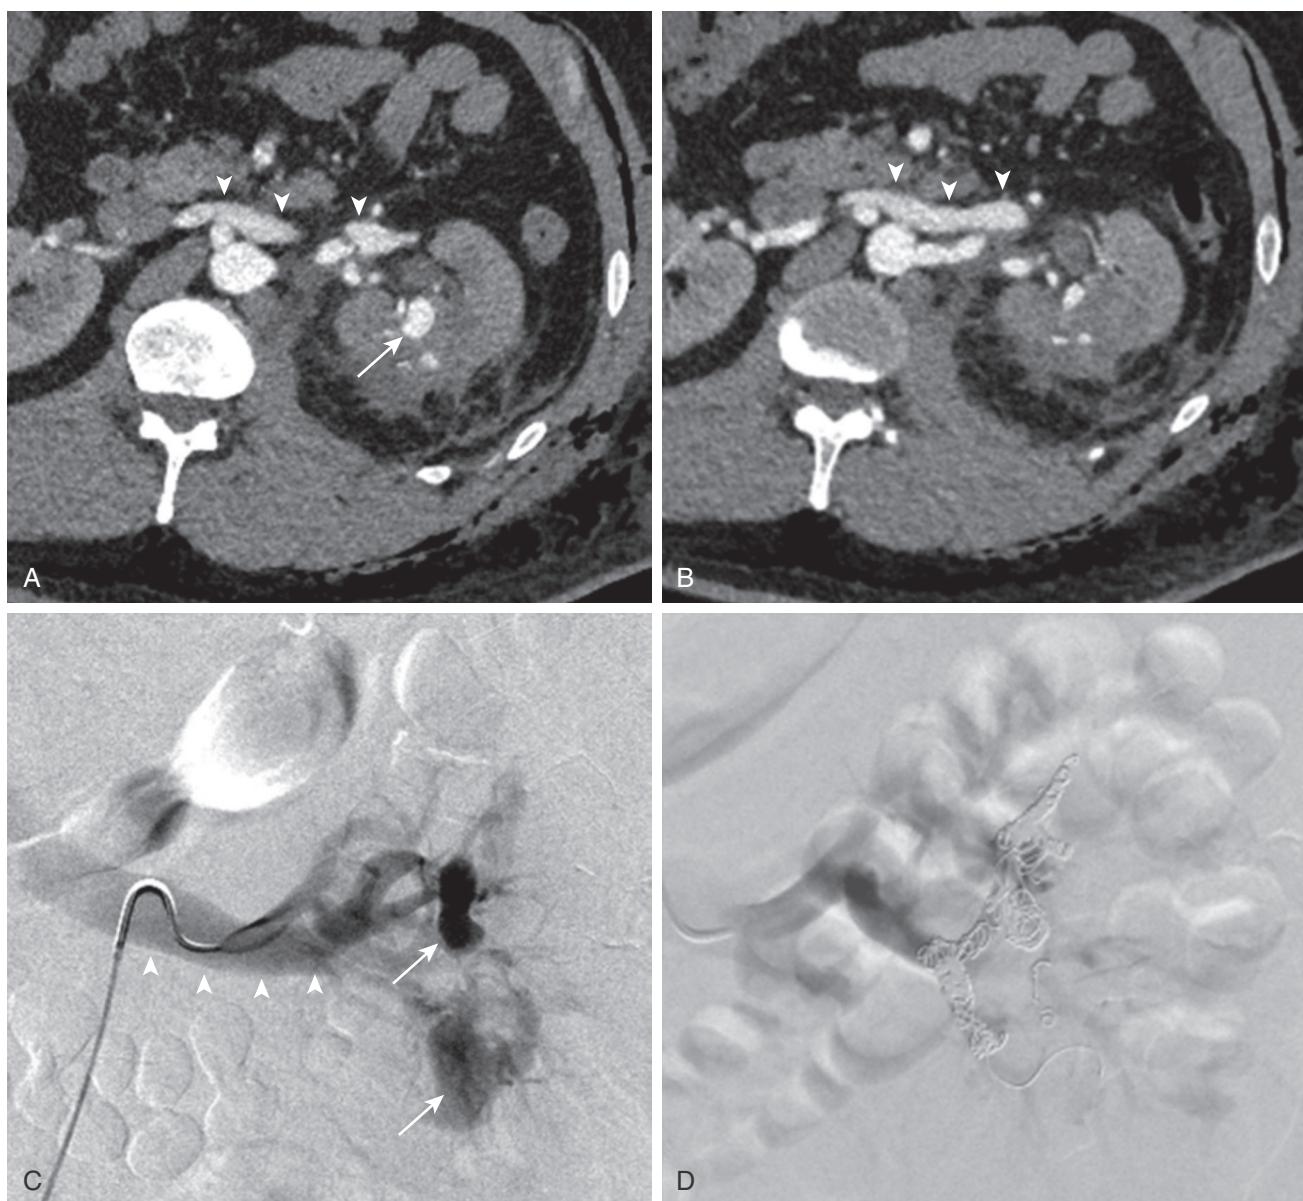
CT and angiogram of a patient with iatrogenic left renal pseudoaneurysms (PSAs) with an arteriovenous fistula (AVF) after partial nephrectomy. Axial arterial-phase CT images (A, B) at the level of kidneys show contrast collection in the left renal parenchyma (arrow), which simultaneously enhances with renal artery and the aorta, consistent with a PSA. In addition, there is early filling of the left renal vein (arrowheads), consistent with a renal AVF. Left perinephric stranding is due to early postoperative changes of partial nephrectomy. Left renal DSA image (C) shows PSAs along the middle and inferior segmental arteries (arrows) with an early draining vein in the arterial phase of the study (arrowheads), consistent with a renal AVF. DSA image of the left renal artery shows coil embolization of the middle and lower pole PSAs and segmental arteries with no opacification of the draining vein.
